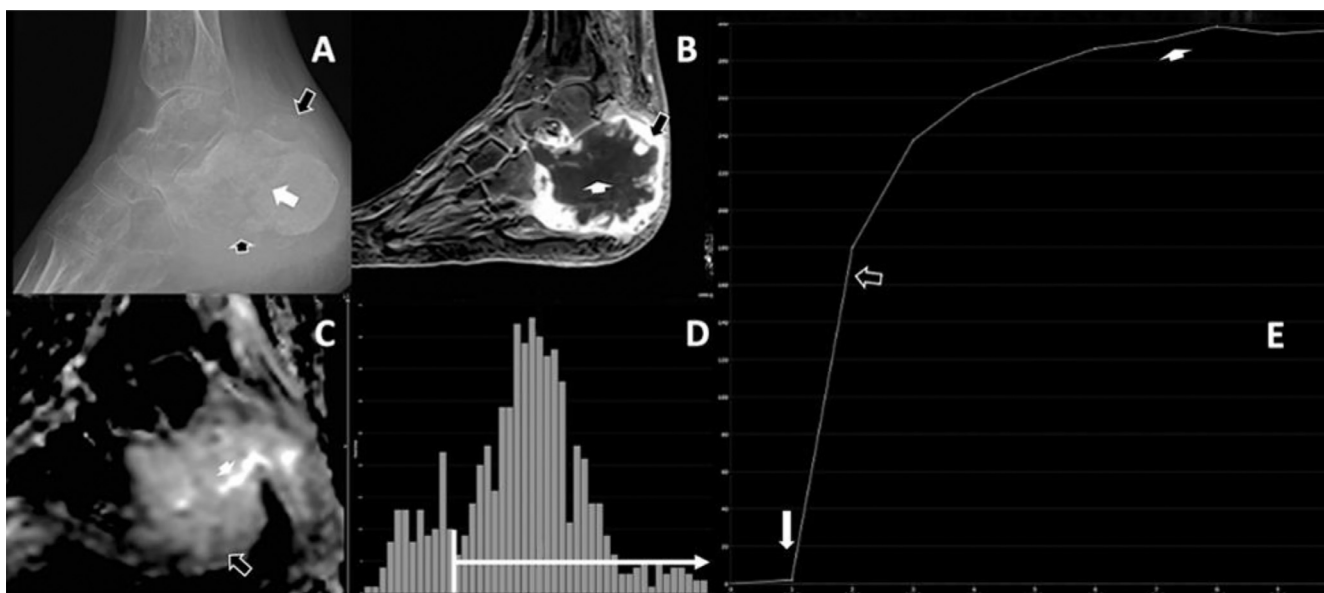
A 37-year-old man with a high-grade chondroblastic osteosarcoma arising from the left calcaneus, after systemic chemotherapy with cisplatin and doxorubicin. (A) Lateral ankle radiograph demonstrates fracture and osteolytic destruction of the calcaneus (white arrow), tumor osteoid (small black arrow), and soft-tissue mass (large black arrow). (B) Sagittal FS T1 contrast-enhanced image demonstrates rim enhancement (black arrow) with central necrosis (small white arrow). (C) The ADC map demonstrates high signal central necrosis (short white arrow), with an ADC of $3.3 \times 10^{-3} \text{ mm}^2/\text{s}$ and a solid peripheral component with lower ADC values (black arrow), ranging from $1.4\text{--}2.3 \times 10^{-3} \text{ mm}^2/\text{s}$ (consistent with granulation tissue). (D) ADC histogram demonstrates that a significant proportion of the tumor pixels are above 2.0 (granulation tissue and necrosis), (white arrow pointing towards the right) and particularly between 2.2 and $2.6 \times 10^{-3} \text{ mm}^2/\text{s}$. (E) Postcontrast DCE PWI kinetics demonstrates a Type 3 curve without early arterial fast wash-in (long white arrow), a continuous up-slope (black arrow) and a late plateau, without a late wash-out (small white arrow).
